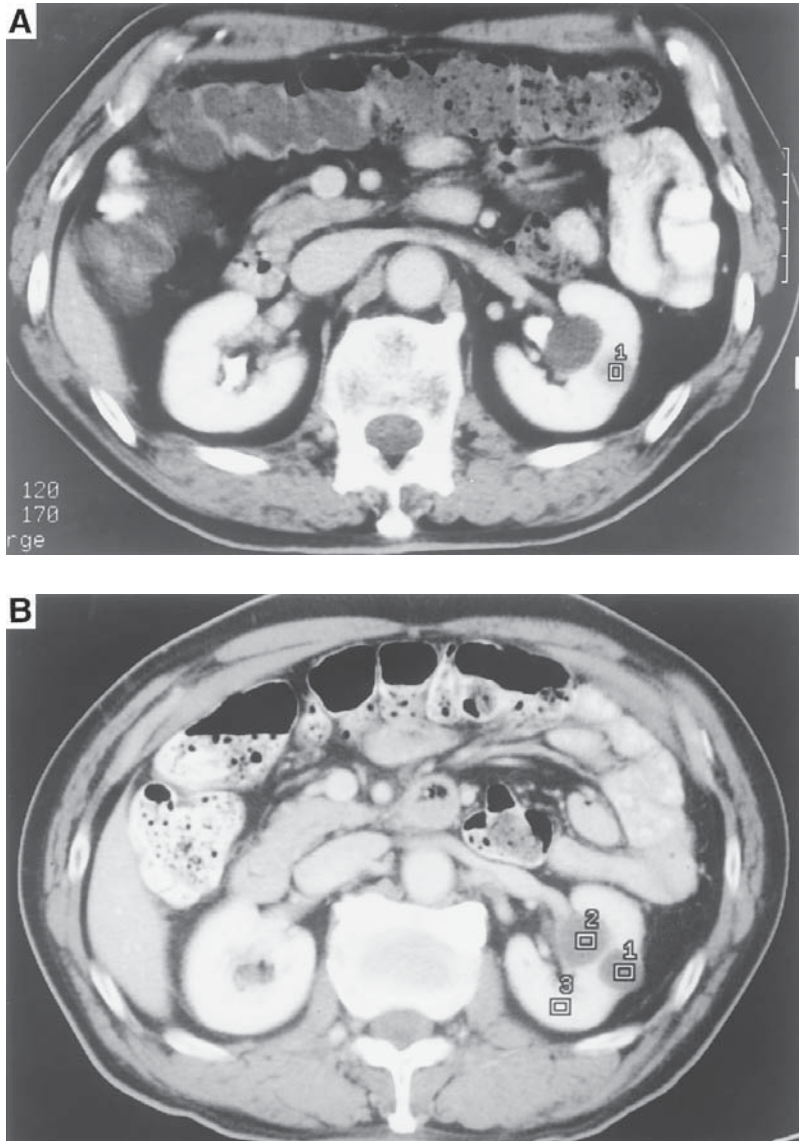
Conventional CT scan (A), interpreted as showing a small, enhancing, parenchymal mass with a density of 54.9 Hounsfield units (HU). When the procedure was performed as a helical CT (B), only the normal parenchyma was enhanced after contrast (208.3 HU); the larger parapelvic cyst had a density of 1.0 HU, and the small parenchymal cyst originally thought to be enhanced had a density of only 5.3 HU.
